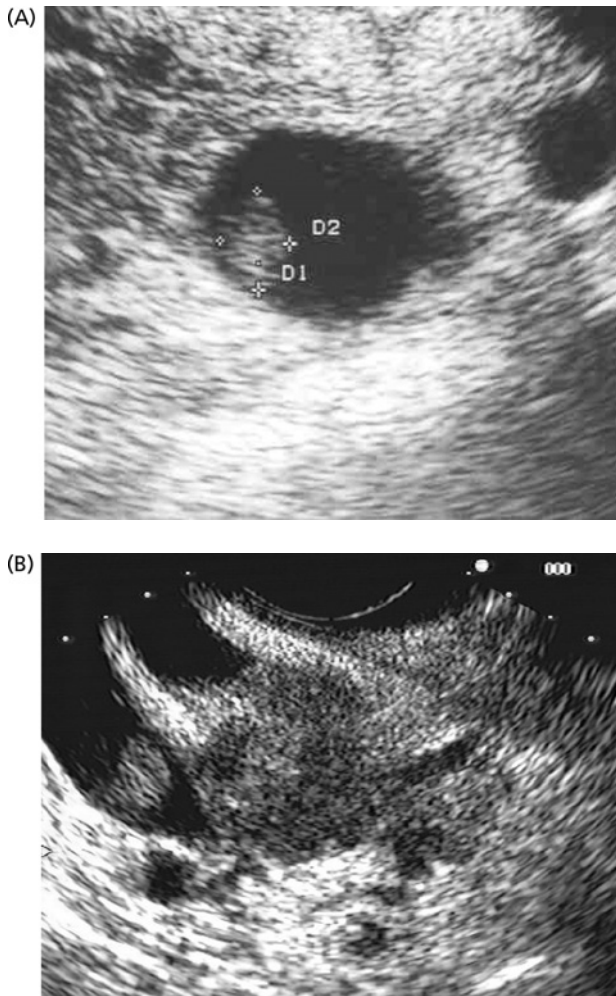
Intravenous filling defects associated with tumor invasion. A small defect is seen in (A) which was not evident on CT. (B) shows a more obvious region of tumor ingrowth directly extending from a large mass which is compressing the portal vein.
